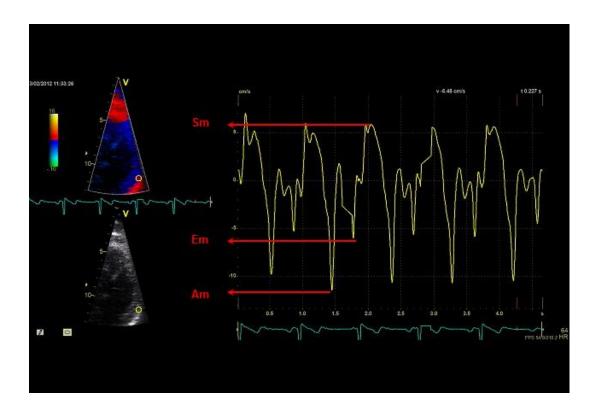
4 Tissue Doppler Imaging echocardiography at the lateral annulus. Sm = peak systolic myocardial velocity, Em, peak early diastolic myocardial velocity, Am = peak late (atrial phase) diastolic myocardial velocity.
